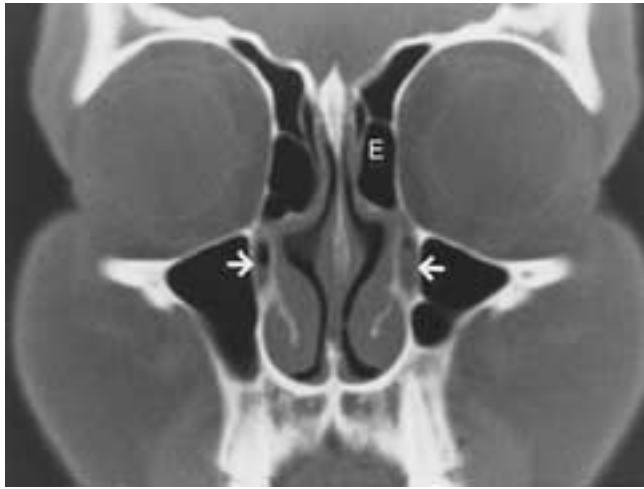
Nasolacrimal canals. Coronal CT scan shows nasolacrimal canals (*arrows*). Note the anterior ethmoid cells (*E*).
